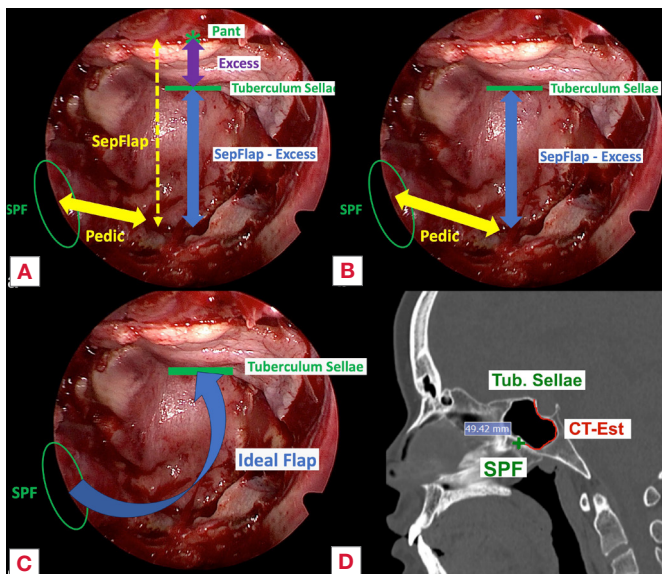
A) Nasoseptal flap in place at the end of surgery. Highlighted in green are the anatomical landmarks used to obtain the measurements of interest; B) Calculation of the Ideal Flap measure (SepFlap - Excess + Pedic); C-D) Representation of the 2 compared measures: Ideal Flap (C) CT-Est (D). Both represent measurements from the sphenopalatine foramen (SPF) to the tuberculum sellae.
